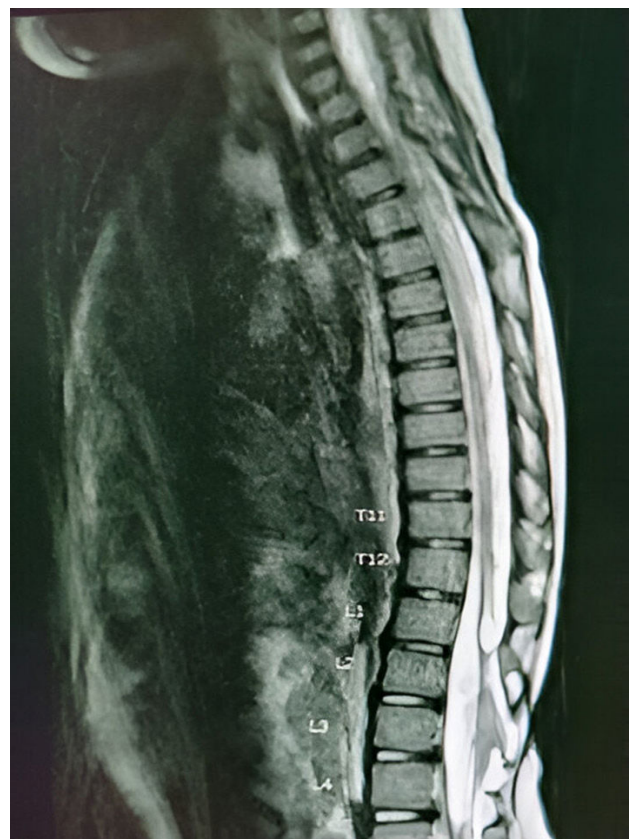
MRI whole spine sagittal view
